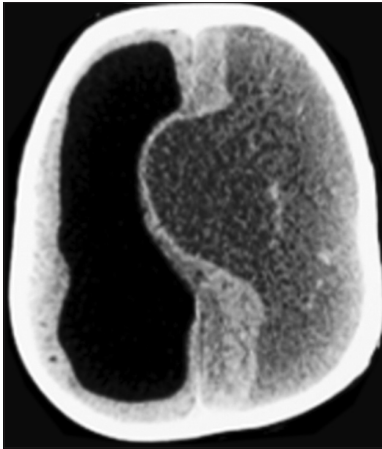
Preoperative CT scan showing giant hemispheric chronic SDH
